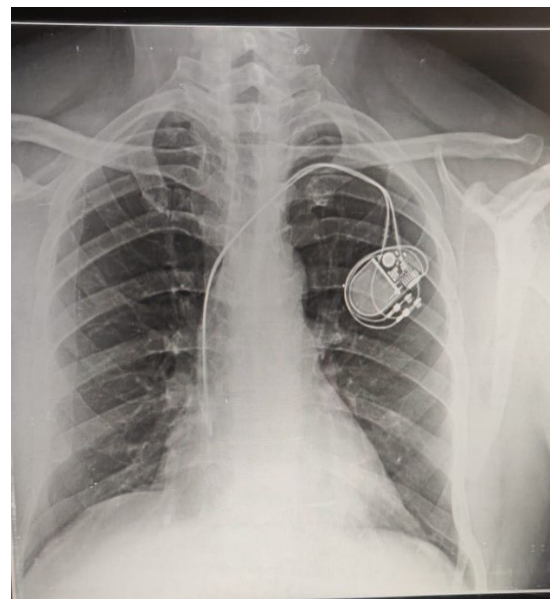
Chest X-ray, showed well-positioned implanted pacemaker leads
